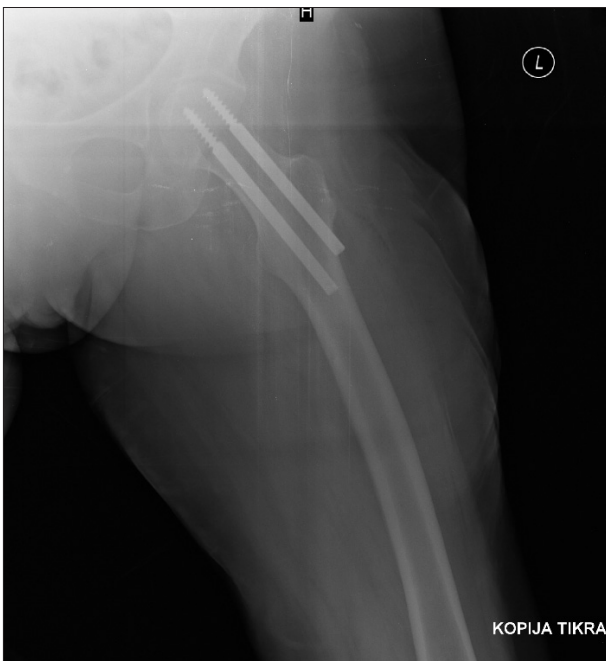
Axial left hip radiograph after the osteosynthesis
